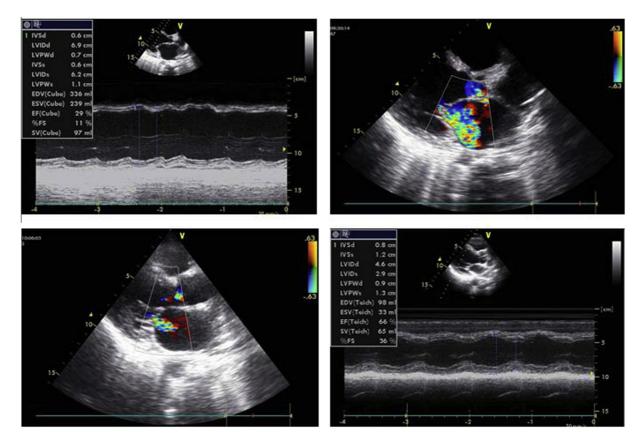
Echocardiography: At the time of diagnosis, dilated, severely hypokinetic LV, LVEF 29% in 2D guided M-mode image (upper left panel) and Grade III mitral regurgitation in 2D guided color flow imaging (upper right panel). One month after treatment, smaller left ventricular cavity with less severe MR in 2D guided color flow imaging (lower left panel). Six months after treatment, normal left ventricular cavity dimensions with normal LVEF in 2D guided M-mode imaging (lower right panel).
